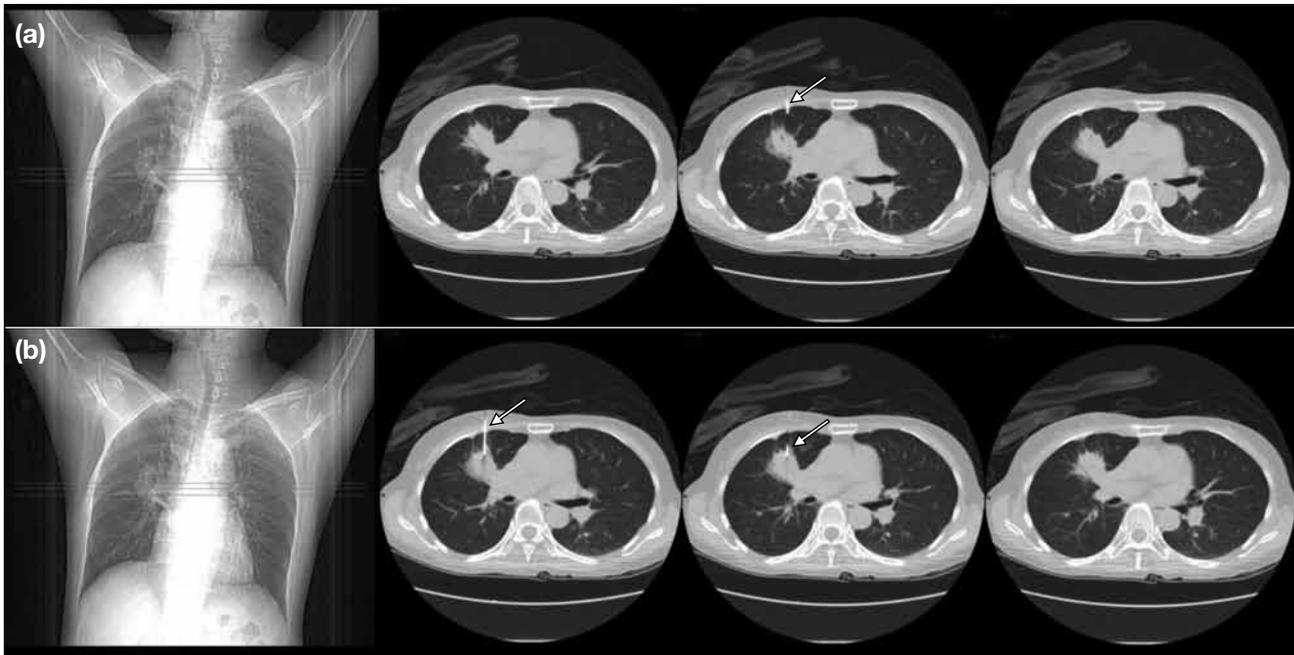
(a) Scanogram and selected axial computed tomography slices during quick-check computed tomography lung biopsy. This method only scans and displays three axial slices after stepping on the foot pedal. Needle adjustment (arrows) is made after assessing the initial images and additional foot pedal is activated (b) until the needle advances to target. In contrast to the multi-slice computed tomography, scanning three axial slices for each step reduces the scan length and radiation dose delivered to the patient.
